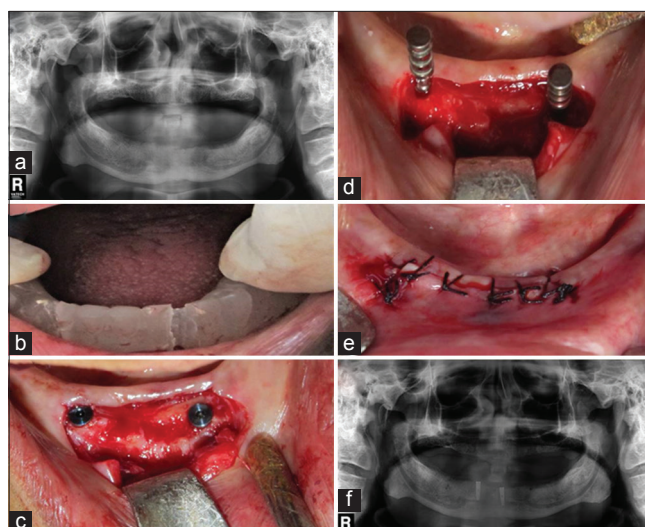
(a) Pre-operative radiograph (b) surgical guide (c) implant placement (d) guide pin verification (e) suture placement (f) post-operative radiograph
